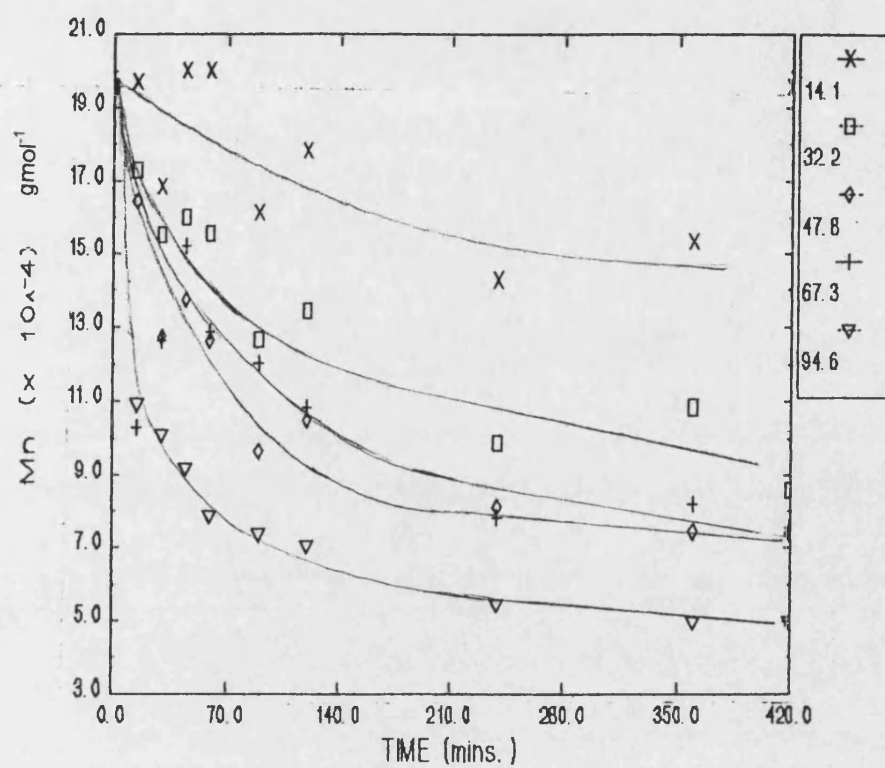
The effect of sonication at various ultrasonic intensities upon  $M_n$
